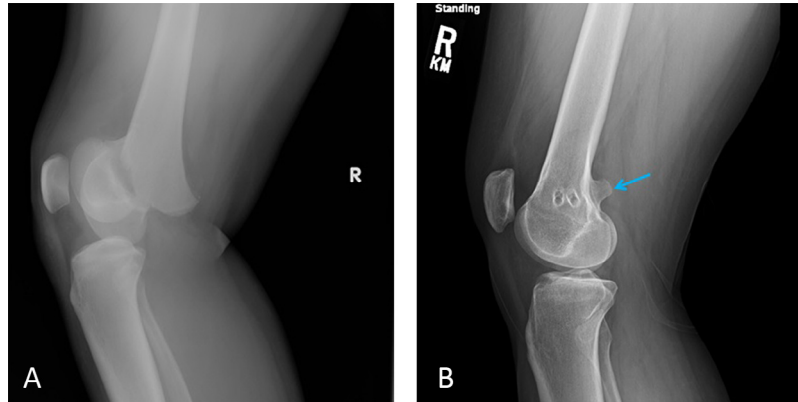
(A) Radiograph of right knee taken in emergency department in 2006 shortly after initial trauma. Salter Harris type II fracture is noted. (B) Radiograph of right knee taken approximately 10 years after the initial inciting traumatic event. Note the osseous protuberance (blue arrow) arising from the posterior aspect of the knee, in the same location as the initial fracture.
